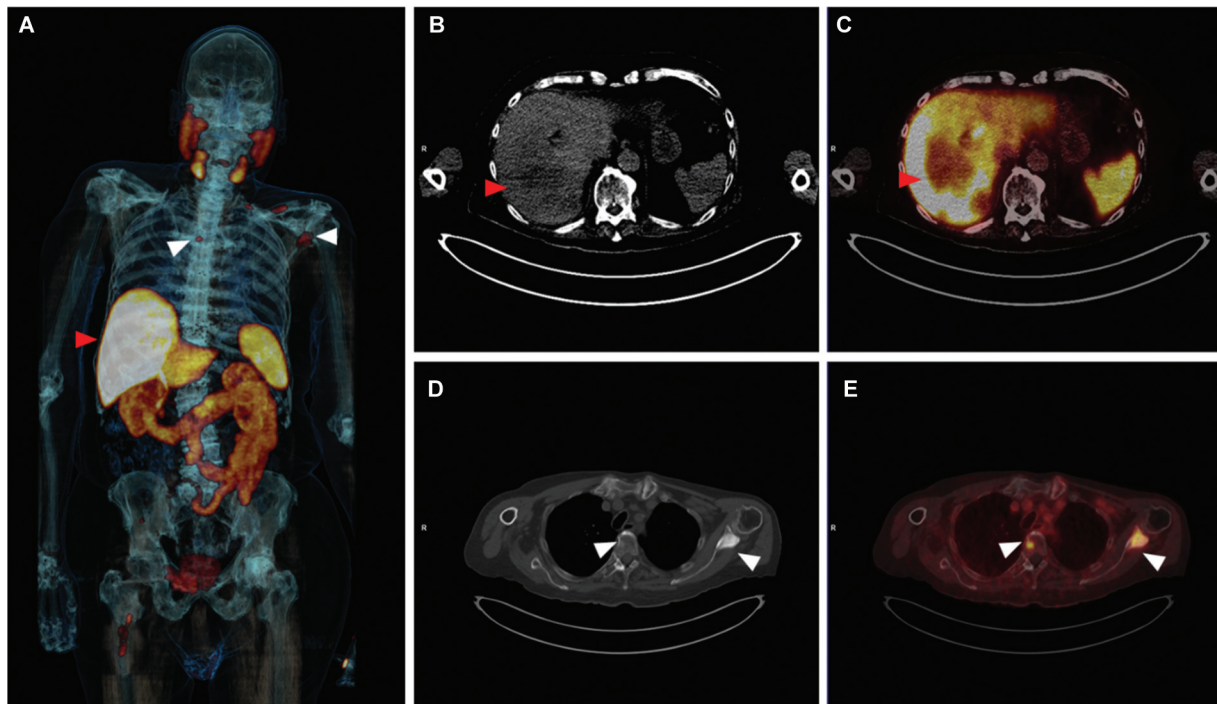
An 84-year-old man with metastatic castration-resistant prostate cancer underwent pretherapeutic ^{18}F -prostate-specific membrane antigen (PSMA)-1007 positron emission tomography/computed tomography (PET/CT) imaging before receiving [^{177}Lu]Lu-PSMA-617 treatment. (A) Maximum intensity projection image of the ^{18}F -PSMA-1007 PET/CT; (B) axial CT image revealing multiple hypodense lesions in the liver; (C) corresponding fused axial ^{18}F -PSMA-1007 PET/CT image showing heterogeneous prostate-specific membrane antigen (PSMA) uptake in these hepatic lesions, as well as high physiologic uptake in the liver parenchyma; (D, E) axial CT image and corresponding fused axial ^{18}F -PSMA-1007 PET/CT image revealing osteoblastic bone lesions at the thoracic vertebra and left scapula, likely PSMA-avid bone metastases.
